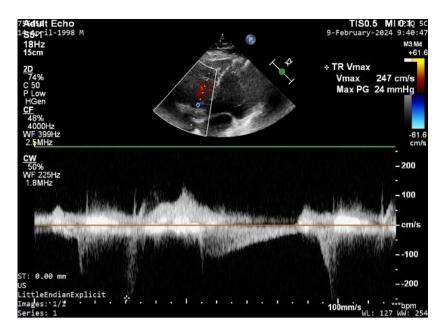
Apical four-chamber view with continuous wave doppler at the tricuspid valve showing tricuspid regurgitation with a peak velocity 247 cm/sec and pressure gradient of 24 mmHg.
